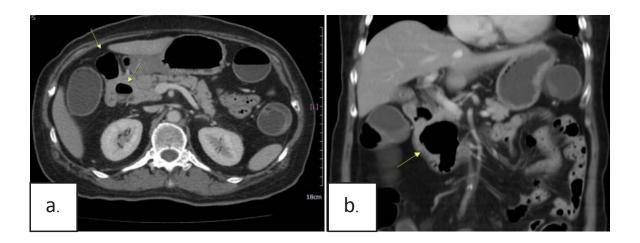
Contrast enhanced CT of the abdomen in a 68 year-old shows incidental finding of two diverticula (arrow in a.), oneat second part of duodenum and the other large one (arrow in b.) at the third part.
